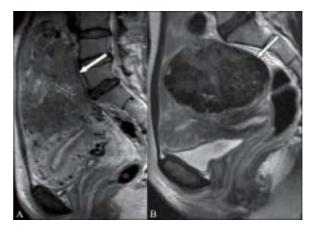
MRI image of uterine myoma
